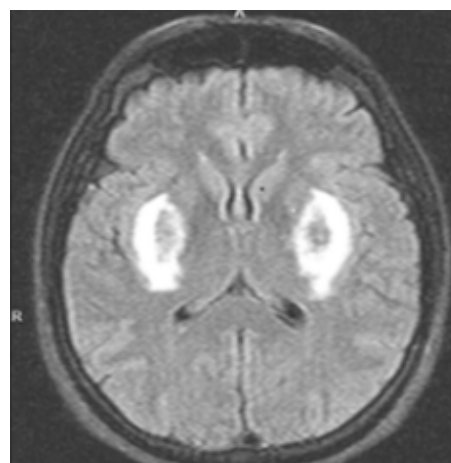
Bilateral putaminal hemorrhagic necrosis areas in acute-subacute period flair MRI
